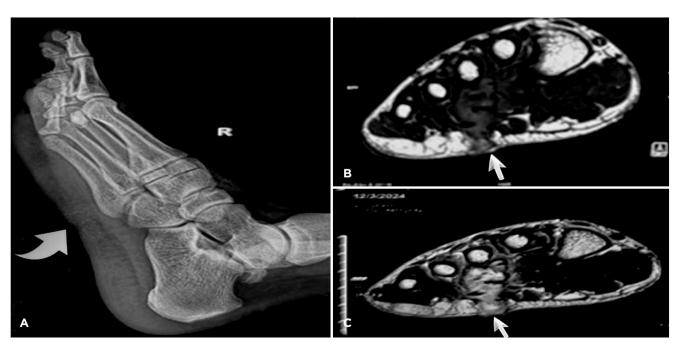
(A) Haziness in the midfoot region on radiograph, lateral view. (B) and (C) Magnetic resonance imaging T1 and T2 axial views showing irregular collection extending from plantar aspect to mid-shafts of third and fourth metatarsals.
